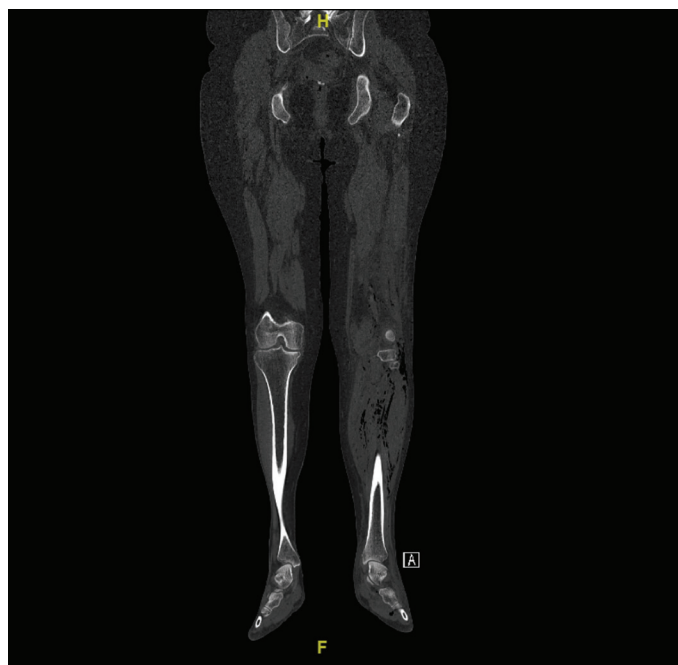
Lower extremity computed tomography. Air densities at the knee and cruris levels
